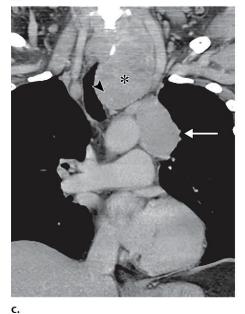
Intrathoracic extension of an 8.5-cm left papillary thyroid cancer in a 60-year-old man. (a) Sagittal gray-scale US image demonstrates a large left thyroid nodule with incomplete visualization (*) of the inferior margin. (b, c) Axial (b) and coronal (c) chest CT images demonstrate the degree of intrathoracic extension (*) of the left papillary thyroid cancer (arrow in b), including displacement of the trachea (arrowhead) to the right, as well as a metastatic mediastinal lymph node (arrow in c).
